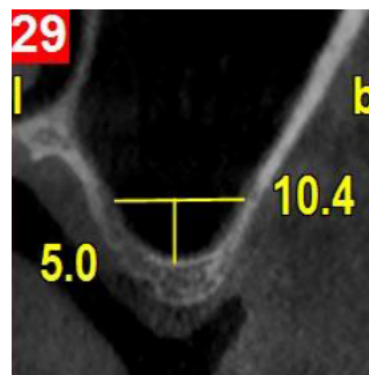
Measuring sinus width at 5 mm superior to the sinus floor in CBCT cross-sectional image.
